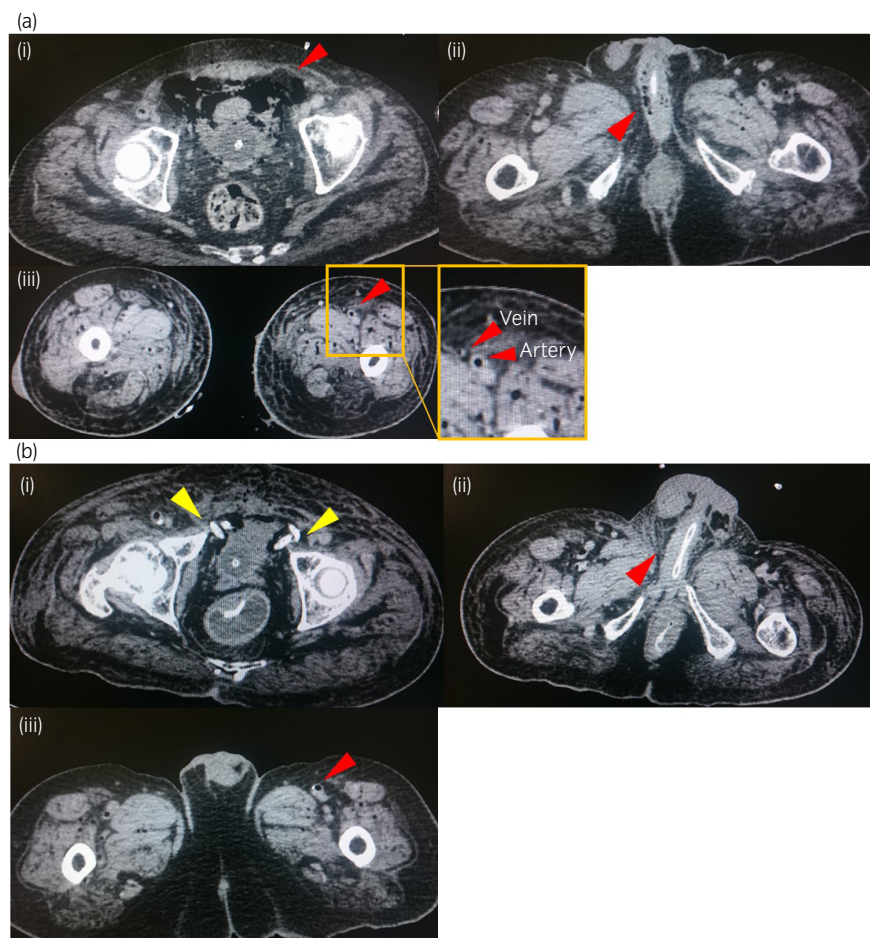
Image findings before and after retroperitoneal drainage. (a) CT of the abdomen and pelvis shows diffuse air within the bladder wall and extending into the retroperitoneal space (i), cavernous body of the penis (ii), muscles of the lower legs and femoral artery and vein (iii). (b) We placed two drainage tubes (yellow triangles) in the retroperitoneal space. Diffuse air decreased postoperatively, but air bubbles in vessels remained (i–iii).
